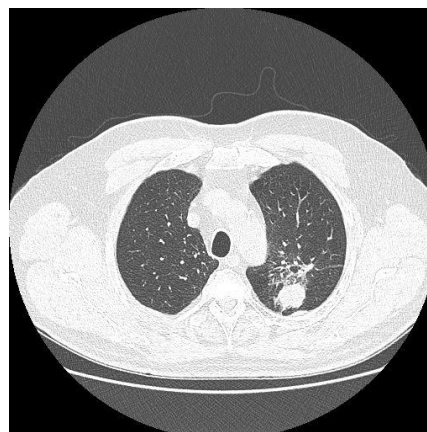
Computed tomography scan of lung (11/2021) – new nodular lesion measuring 24×20 mm in segment 1+2 of upper lobe of left lung previously absent.
